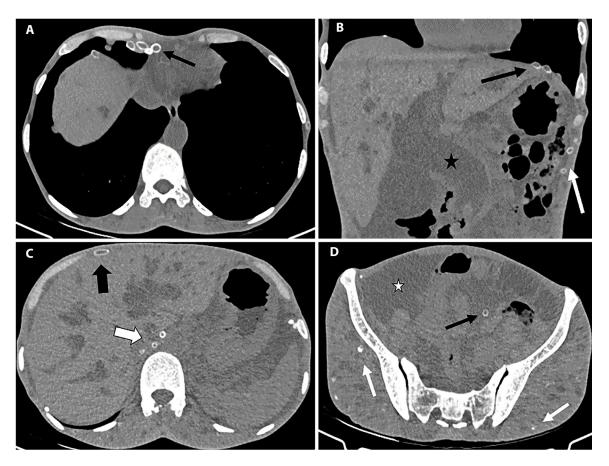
Noncontrast CT images of abdomen and pelvis showing multiple calcified lesions in various organs: (A) Along mediastinal pleura (black arrow). (B) Along left diaphragm (black arrow) and peritoneal lining (white arrow); dilated common bile duct also present (black star). (C) Along right crus of diaphragm (boxed white arrow) and liver capsule (boxed black arrow). (D) In mesentery (black arrow) and bilateral gluteal muscles (white arrow); ascites (white star) also present.
